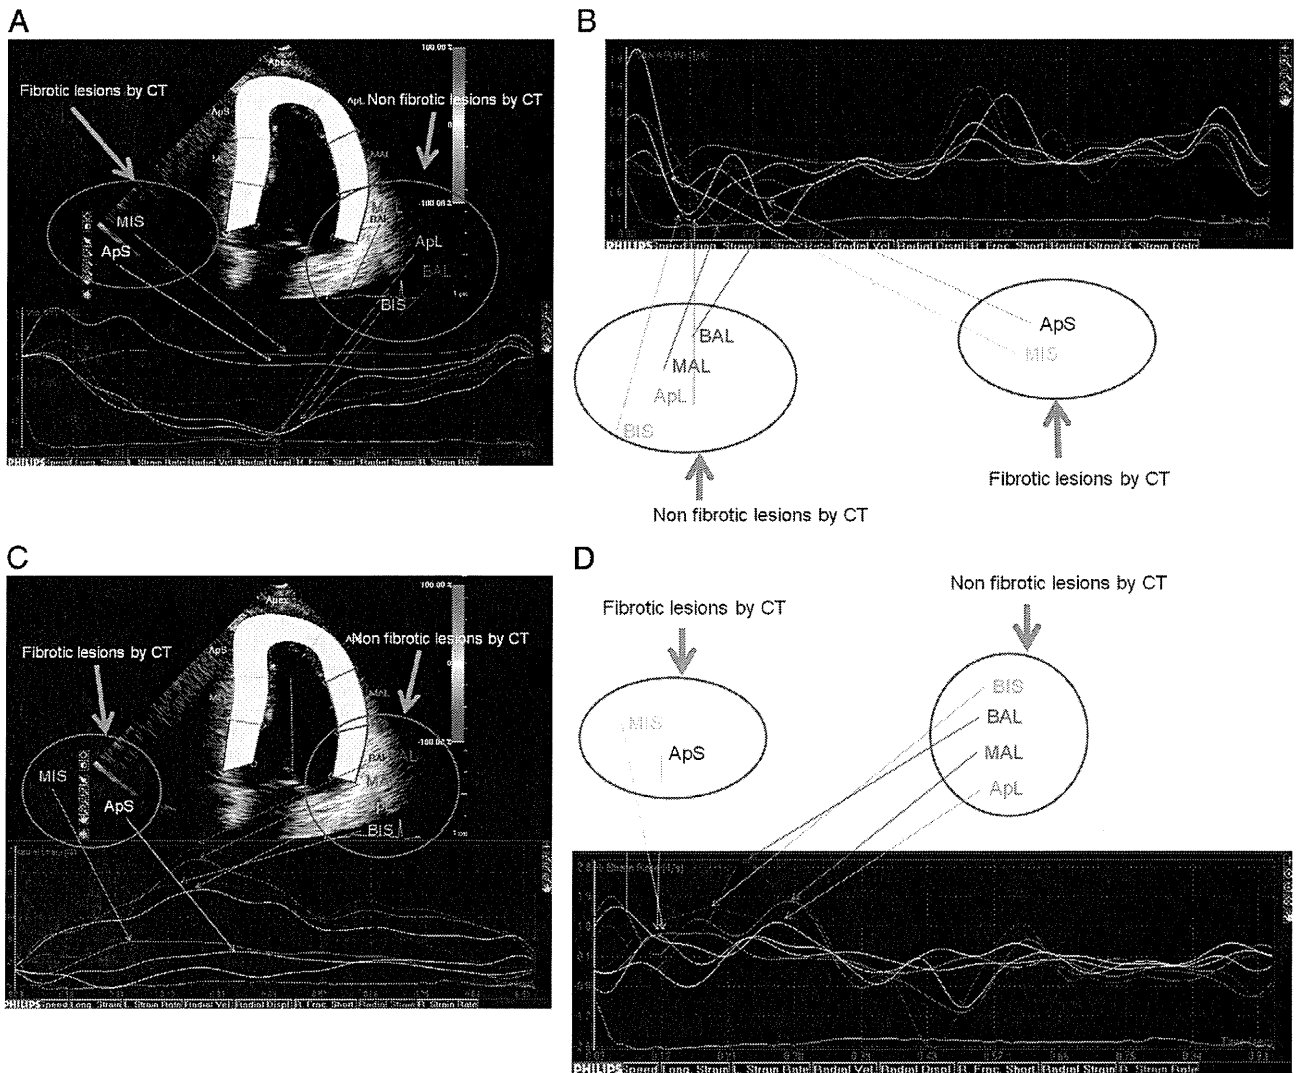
Color-coded strain images acquired by transthoracic echocardiogram and charts in the same subject with hypertrophic cardiomyopathy (asymmetrical septal hypertrophy type) as that shown in Fig. 1. (A) Upper part represents four chamber views of transthoracic echocardiogram at end diastole. Bottom represents regional longitudinal strain values in each lesion during one cardiac cycle. Absolute values of longitudinal strain were lower in mid interventricular septum (MIS) and apical septum (ApS) in which fibrotic lesions were confirmed on CT as represented in Fig. 1, than in mid anterolateral (MAL), apical lateral (ApL), basal anterolateral (BAL) and basal interventricular septum (BIS) in which fibrotic lesions were not observed. (B) Regional longitudinal strain rates (LSR) in the same subject with HCM. There were non-remarkable differences of regional peak LSR between fibrotic (ApS, and MIS) and non-fibrotic lesions (BAL, MAL, ApL and BIS) on CT (C) Upper part represents four chamber views of transthoracic echocardiogram at end diastole. Bottom represents radial strain values in each lesion during one cardiac cycle. Absolute values of radial strain were lower in MIS and ApS in which fibrotic lesions were observed on CT as represented in Fig. 1, than in BAL, MAL, ApL, and BIS in which fibrotic lesions were not observed. (D) Regional radial strain rates (RSR) in the same subject with HCM. There were non-remarkable differences of regional peak RSR between fibrotic (ApS, and MIS) and non-fibrotic lesions (BAL, MAL, ApL and BIS) on CT.
